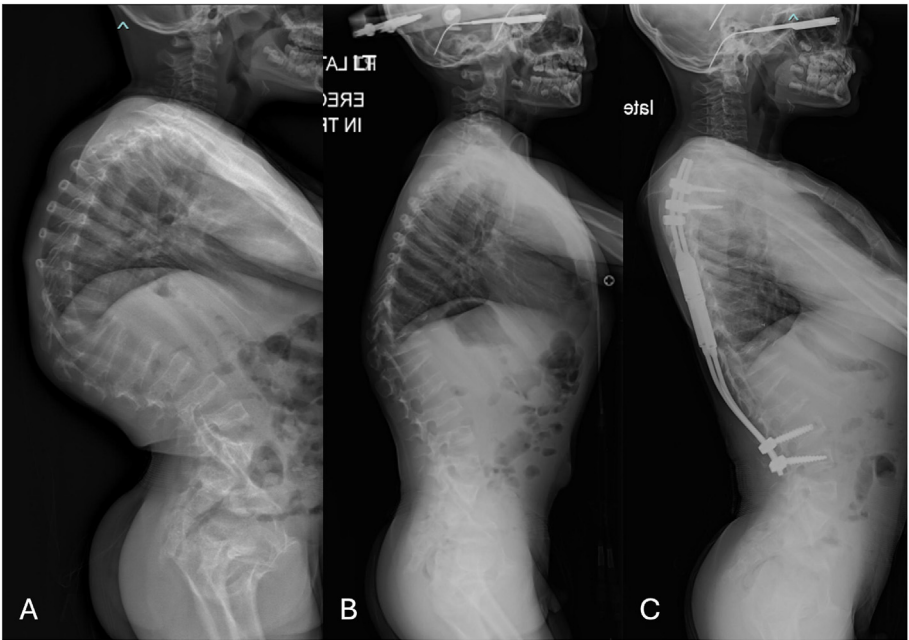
(A) Preoperative lateral radiograph of a 7-year-old boy with metatropic dysplasia and 110 degrees of thoracic kyphosis. (B) Improvement of thoracic kyphosis to 70° following apical anterior thoracoscopic releases and 4 weeks of HGT at 50% body weight. (C) Final growing rod construct out of traction with 35 degrees of thoracic kyphosis. HGT, halo-gravity traction.
